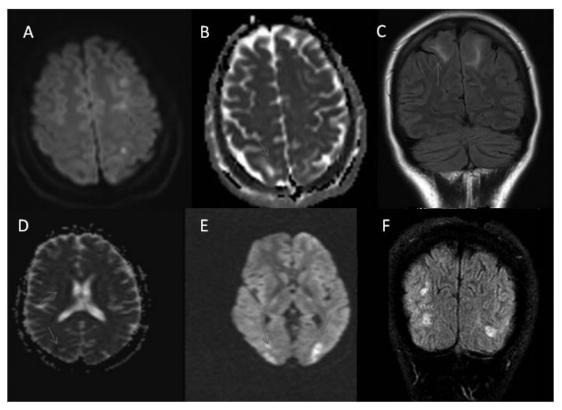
Cranial MRI findings on DWI(A, E), ADC(B,D) and FLAIR(C,F) sequences(blue arrows shows lesions)
